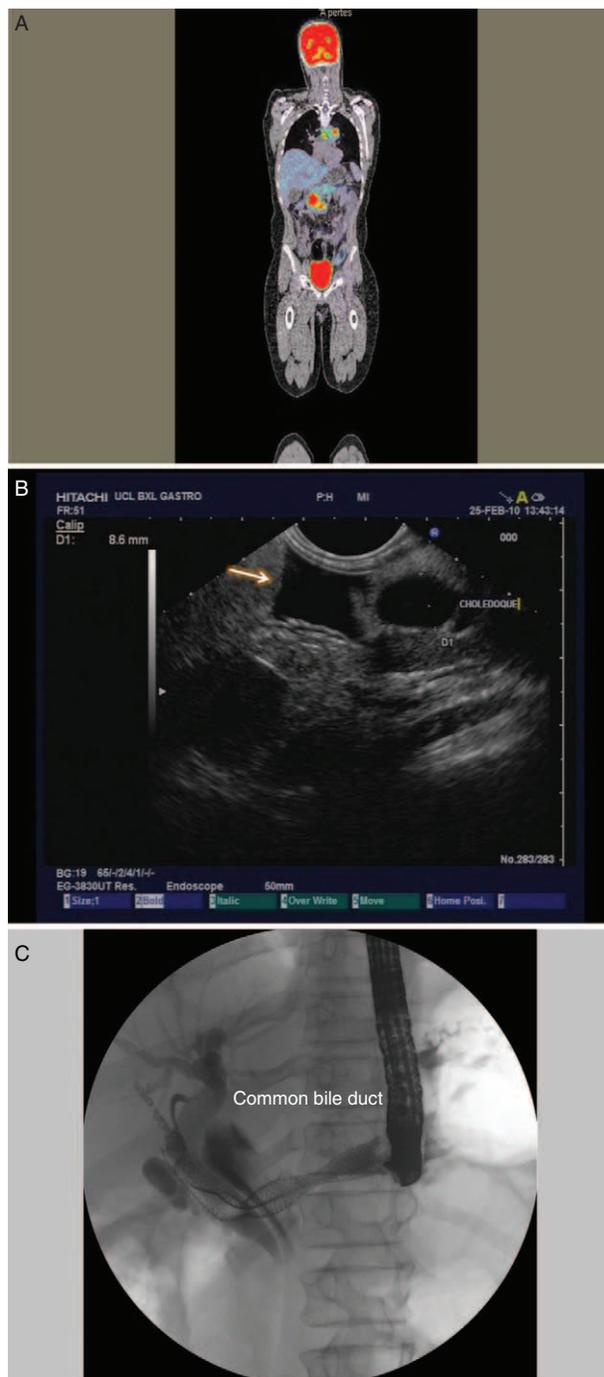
EUS-guided biliary drainage (patient number 31). (A) PET-CT showing a large pancreatic mass. (B) Endosonographic picture of a dilated CBD and presence of ascites (arrow). (C) Fluoroscopic imaging of the 2 covered metallic expandable stents placed in the CBD, with some surrounding leakage. CBD = common biliary duct; EUS = endoscopic ultrasound; PET-CT = positron emission tomography-computed tomography.
